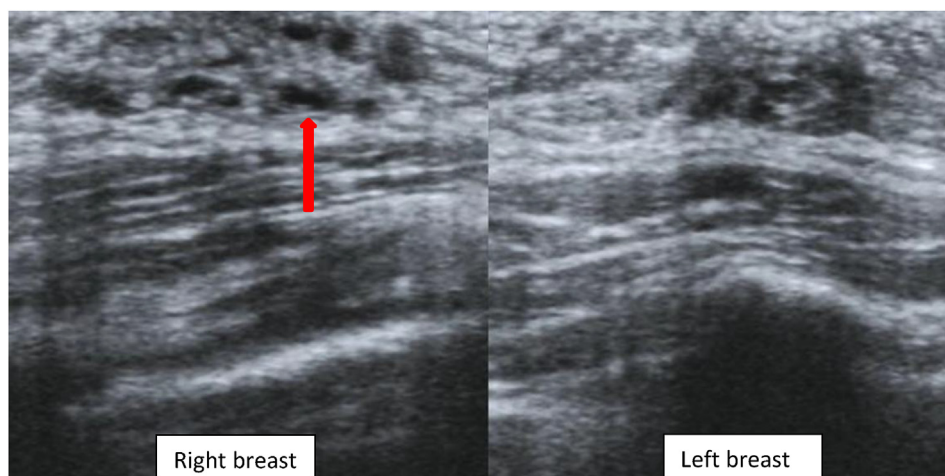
Follow up ultrasound of the breast three months later: there has been decrease in the degree of ductal dilatation bilaterally (thin arrow:glandular tissue) Right breast Left breast.
